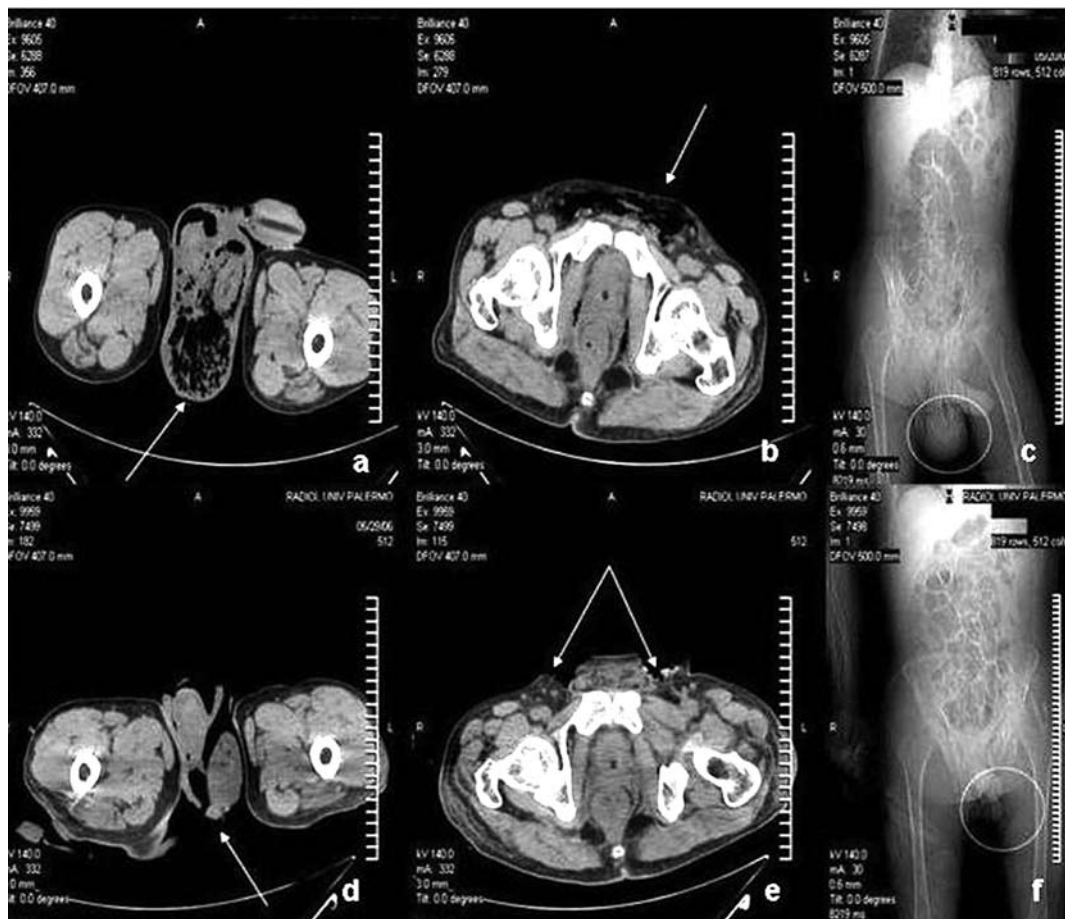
CT scan before (a,b,c) and after (d,e,f) surgery.
